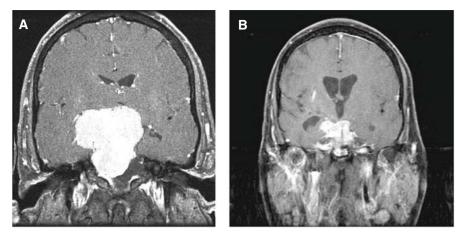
Transclival approach for petroclival meningioma. Preoperative (A) and postoperative (B) MRI of the brain showing significant debulking of a large petroclival meningioma via EEA
